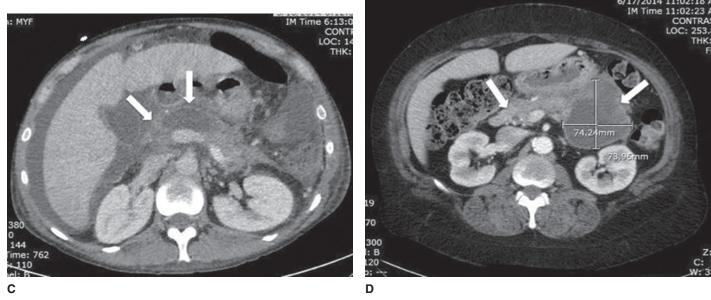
Abdominal IV contrast-enhanced CT scans showing: A. normal pancreas (*arrow*) with smooth outer contours, clear demarcation between pancreas and surrounding tissues, and without peripancreatic fluid; B. mild pancreatitis with indistinct pancreatic borders (*left arrow*), pancreatic edema, and peripancreatic fluid (*right arrow*); C. edematous pancreas with indistinct borders (*left arrow*) and area of nonenhancing parenchyma pancreatic necrosis with area of acute pancreatic necrosis (low attenuation representing nonenhancing parenchyma; *right arrow*); and D. edematous pancreas with indistinct pancreatic borders (*left arrow*) and a pseudocyst in the pancreatic tail (*right arrow*). [Images contributed by Bart Besinger, MD, FAAEM.]
